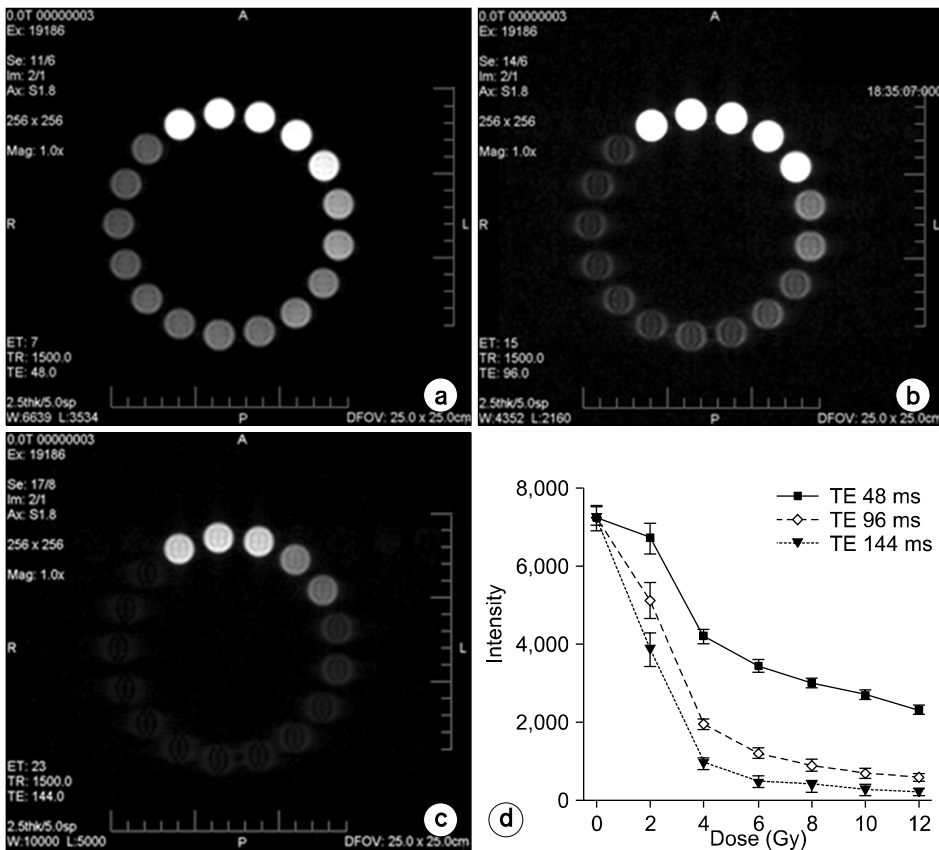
The variance of pixel value in MRI image. Acquisition TE times (a) 48 ms, (b) 96 ms, (c) 144 ms, (d) The dose vs. pixel intensity curve.
